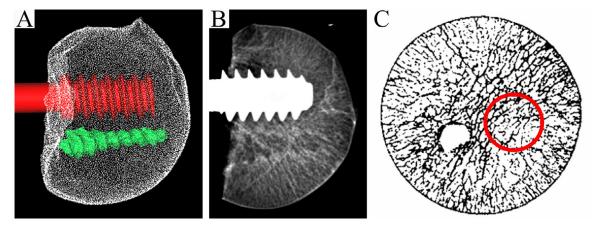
The screw insertion was first planned based on the μ CT images. B) Actual insertion location is exemplified based on radiograms. C) μ CT image highlighting the region where the DHS was inserted and the BV/TV quantified.
